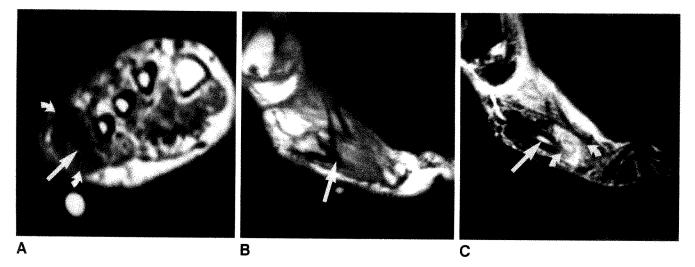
Osteomyelitis of fifth metatarsal in 62-year-old man. Abnormal bone-marrow signal (straight arrow) of distal fifth metatarsal is shown on the axial T1-weighted (483/20) (A), sagittal T1-weighted (683/20) (B), and sagittal short-tau inversion recovery (STIR) (2233/125) (C) images. Soft-tissue abscess (curved arrows) adjacent to osteomyelitis can also be seen on T1-weighted (A) and STIR (C) images, but is better shown on STIR image. Note suppressed fat signal within normal bone marrow on STIR image (C).
